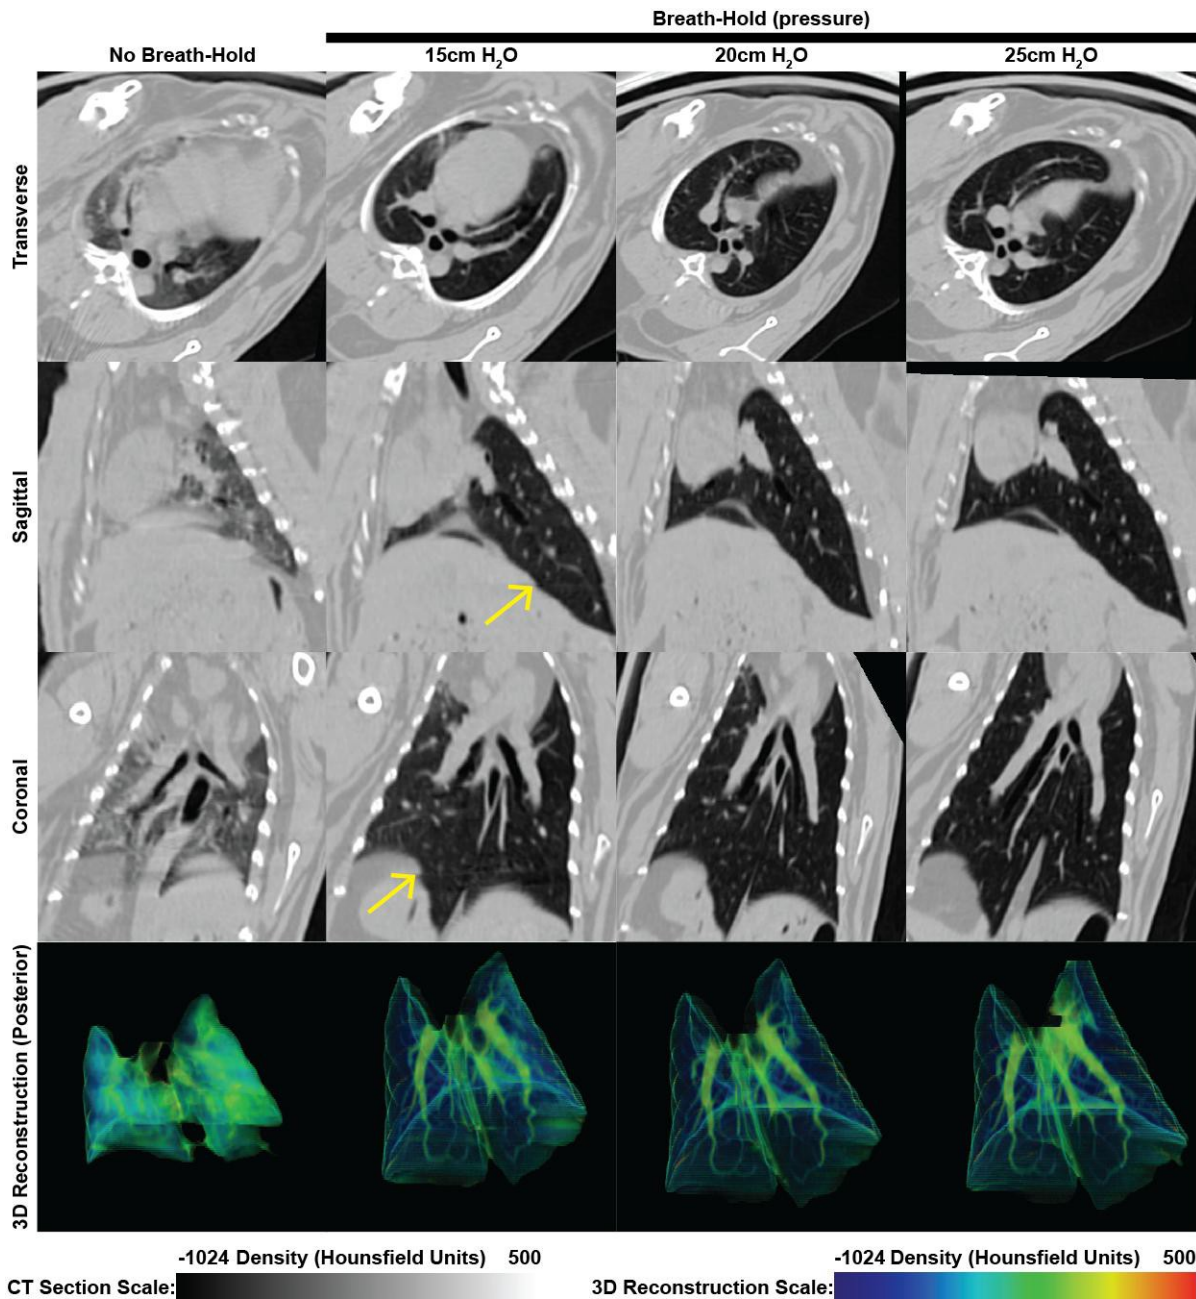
Breath-holding using custom designed device significantly improved image quality, and allowed for set pressure breath holds: Representative CT slices are displayed above. Compared to no breath-hold, all breath-hold images at every pressure tested offer significant improvement in image quality. A small amount of motion artefact is noted in the 15cmH₂O (yellow arrow). The remaining images, although not artefact free (there is a motion artefact generated by uneven flooring in the imaging facility, a problem which was subsequently corrected), are dramatically more informative than the non-breath hold images.
